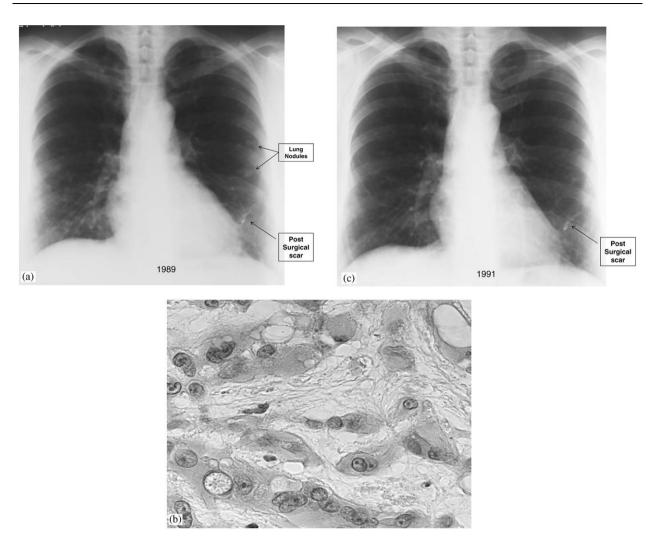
Pulmonary intravascular bronchoalveolar tumor at initial presentation. (a) Chest radiograph shows bilateral lung infiltrated and a postoperative scar. (b) Pulmonary IVBAT lung biopsy from 1984 revealed epithelioid cells with large clear intracytoplasmic vacuoles consistent with pulmonary IVBAT. (c) Chest radiograph shows complete resolution of lung nodules.
